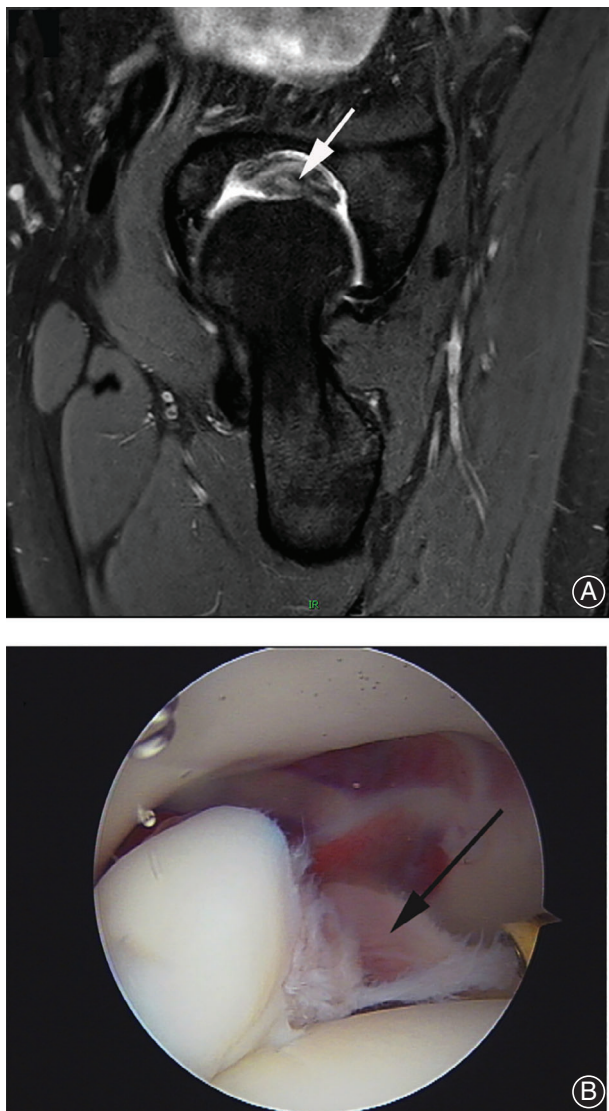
Twenty-seven-year-old female dancer sustained a hip injury during jumping in a performance. (A) MRI showed partial tear of ligamentum teres (arrow). (B) Arthroscopic view of the partial tear of ligamentum teres (arrow).
